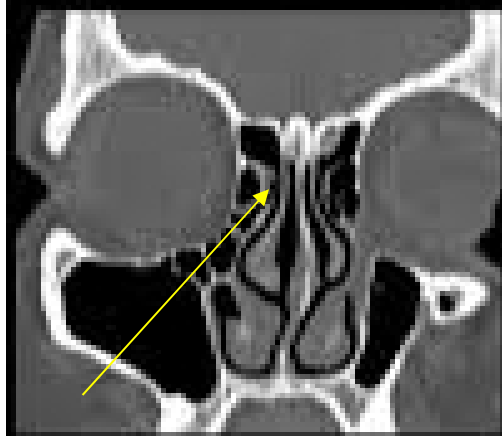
CT image showing Frontal Recess(arrow)
